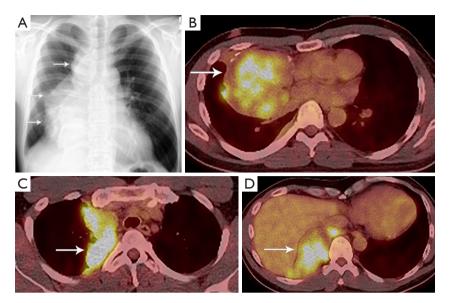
Chest radiograph and PET/CT of the primary tumor. (A) Frontal chest radiograph shows a large right prevascular (anterior) mediastinal mass (arrow). (B-D) Axial PET/CT shows an FDG avid right prevascular (anterior) mediastinal mass (arrow) extending into the lung (B) with nodular right pleural thickening involving the right mediastinal pleura (arrow) in the upper right hemithorax (C) and the diaphragmatic pleura (arrow) (D) consistent with right pleural metastases. PET-CT, positron emission tomography-computed tomography; FDG, fluorodeoxyglucose.
